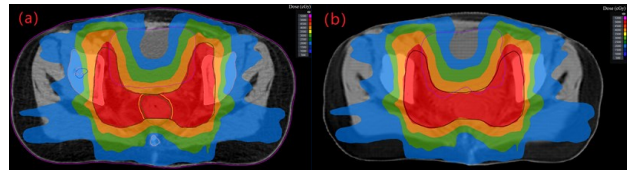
shows the difference in dose between raw CT and sCT for one example patient. The figure shows the dose distribution of 50Gy, 40Gy, 30Gy, and 20Gy for the original CT, while the figure b shows results for sCT.
